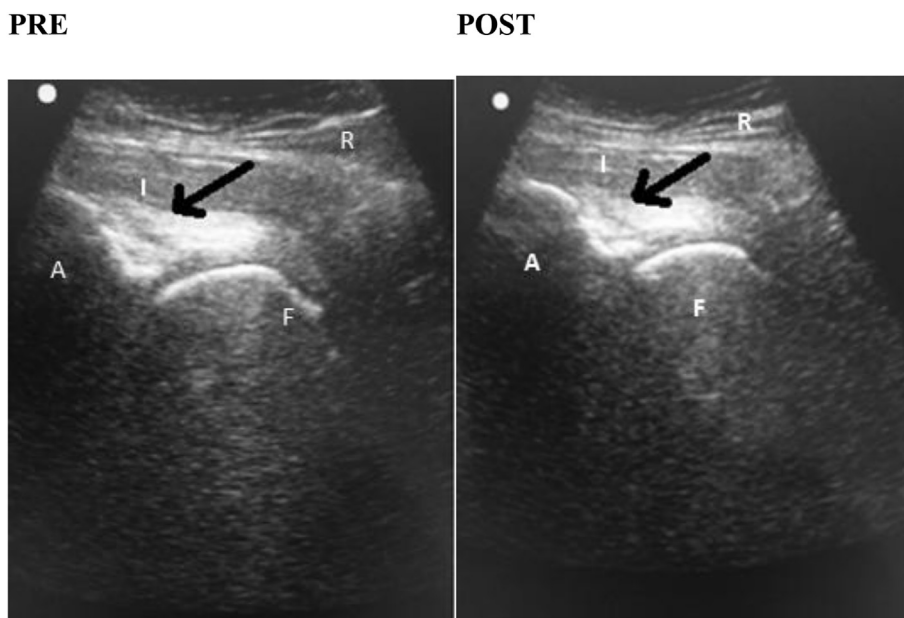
Repeat sonographic image taken after 4 weeks showing healing of the iliopsoas tear with a decrease in anechoic fluid over the femoral head (adjacent comparison image).
